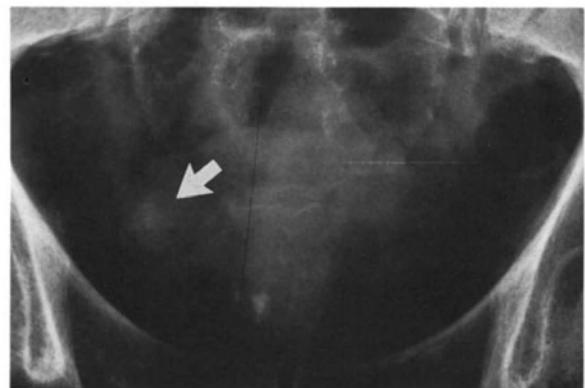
Plain film. There is a little calcification above the symphysis pubis, prostatic in nature, and there is faint calcification of the transitional cell bladder tumor (arrow).
